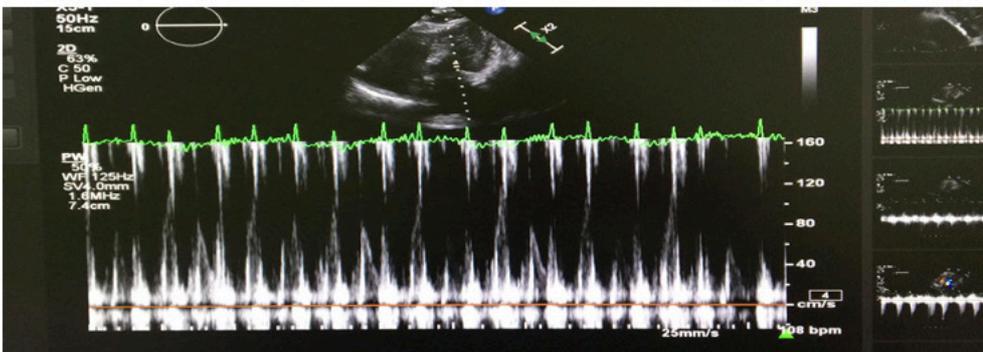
In the left ventricle inflow pulse wave doppler evaluation, a respiratory switch within physiological ranges was observed. Significant construction finding was not detected.
